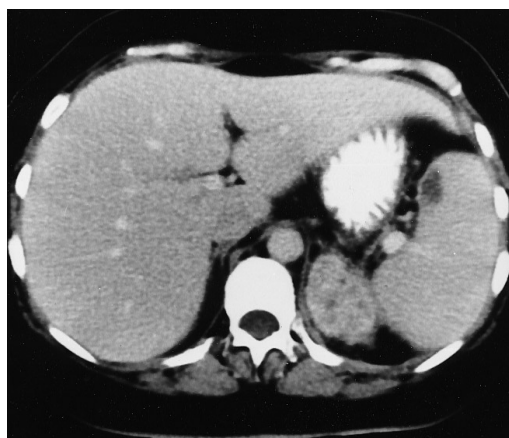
Contrast-enhanced axial CT. Left adrenal mass with an inhomogeneous enhancement indicating necrosis. A small low attenuation area may also be seen in the spleen
